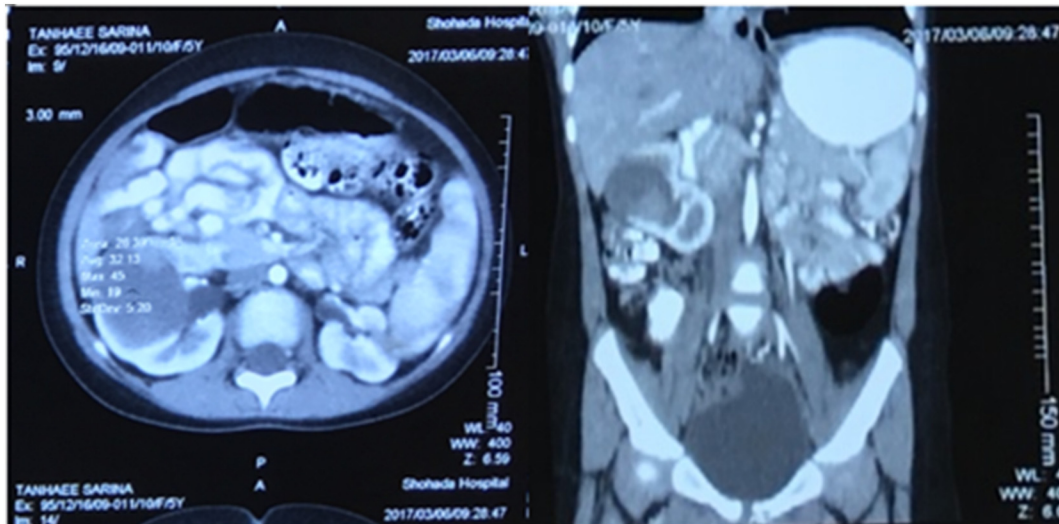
Computed tomographic scan of the abdomen displayed a hypodense well defined soft tissue mass in kidney parenchyma.
